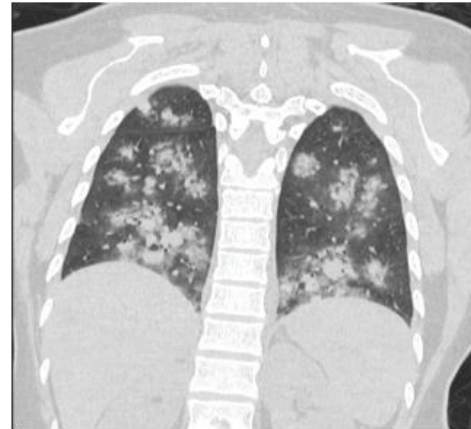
CECT Thorax – Coronal view: nodular consolidations with peripheral GGOs, no post-contrast enhancement, and reduced nodule count compared to prior HRCT, supportive of a viral aetiology.
